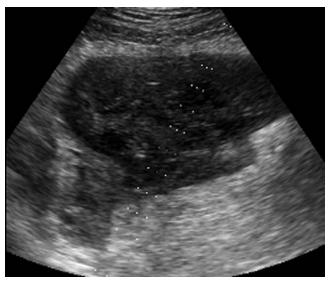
Transverse sonogram of the right adnexa.
